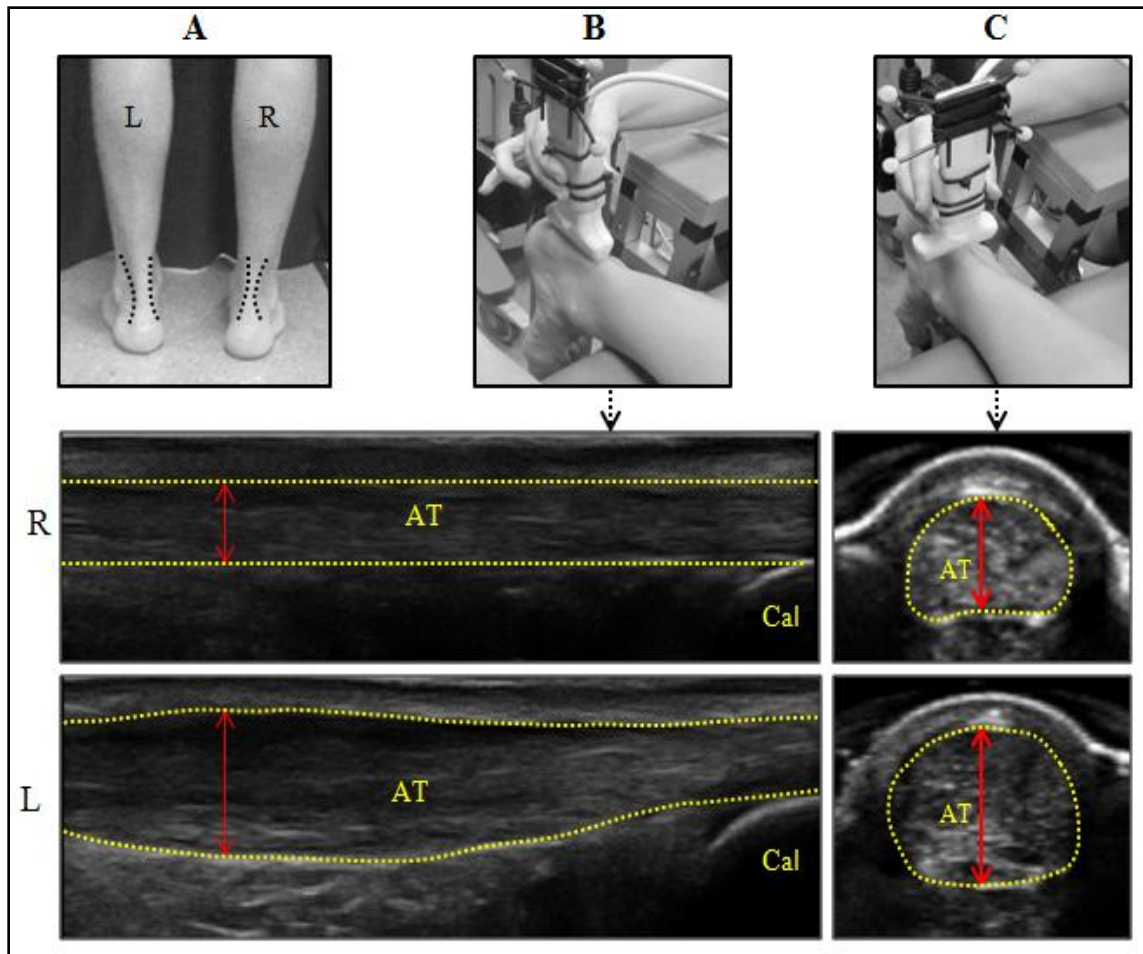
(A) Posterior view of a participant with mid-portion Achilles tendinopathy showing swelling and thickening over the involved tendon (left side). Black dotted lines outline the tendon. The longitudinal (B) and transverse (C) two-dimensional ultrasound images of Achilles tendon (AT) of the participant show a thickened AT mid-portion with irregular structure on the left side (L) and a normal structure on the right side (R). Yellow dotted lines outline the tendon. The double-headed arrows indicate AT thickness. Cal, calcaneus.
